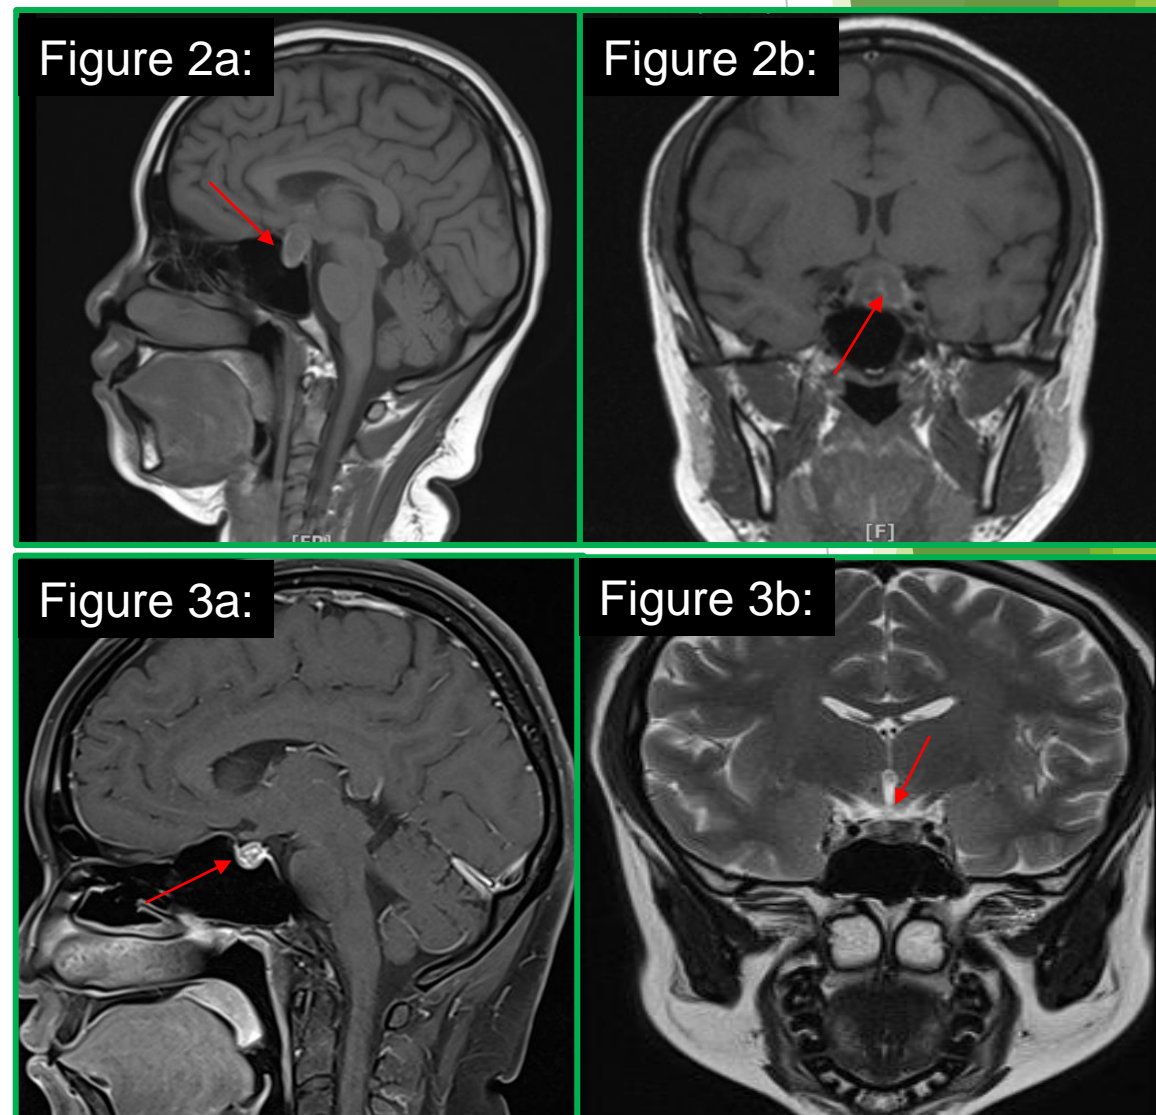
Sagittal MRI demonstrates an enlarged pituitary gland with compression to pituitary stalk (arrow).
